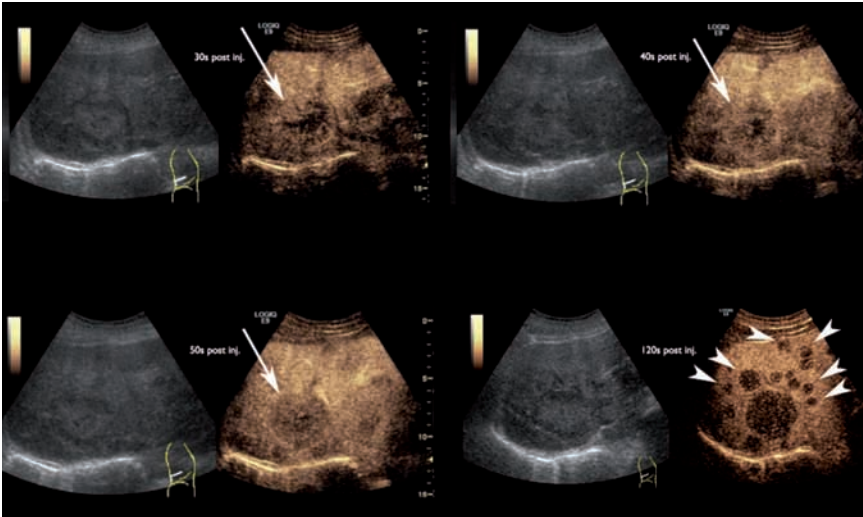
Ultrasound contrast agent for characterization and detection. Fundamental phase image shows almost isoechoic adenocarcinoma metasis with hypoechoic rim. After contrast agent there is rim enhancement of the lesion with wash-out (arrows). In the liver-specific phase, multiple additional lesions are visualized (arrowheads).
